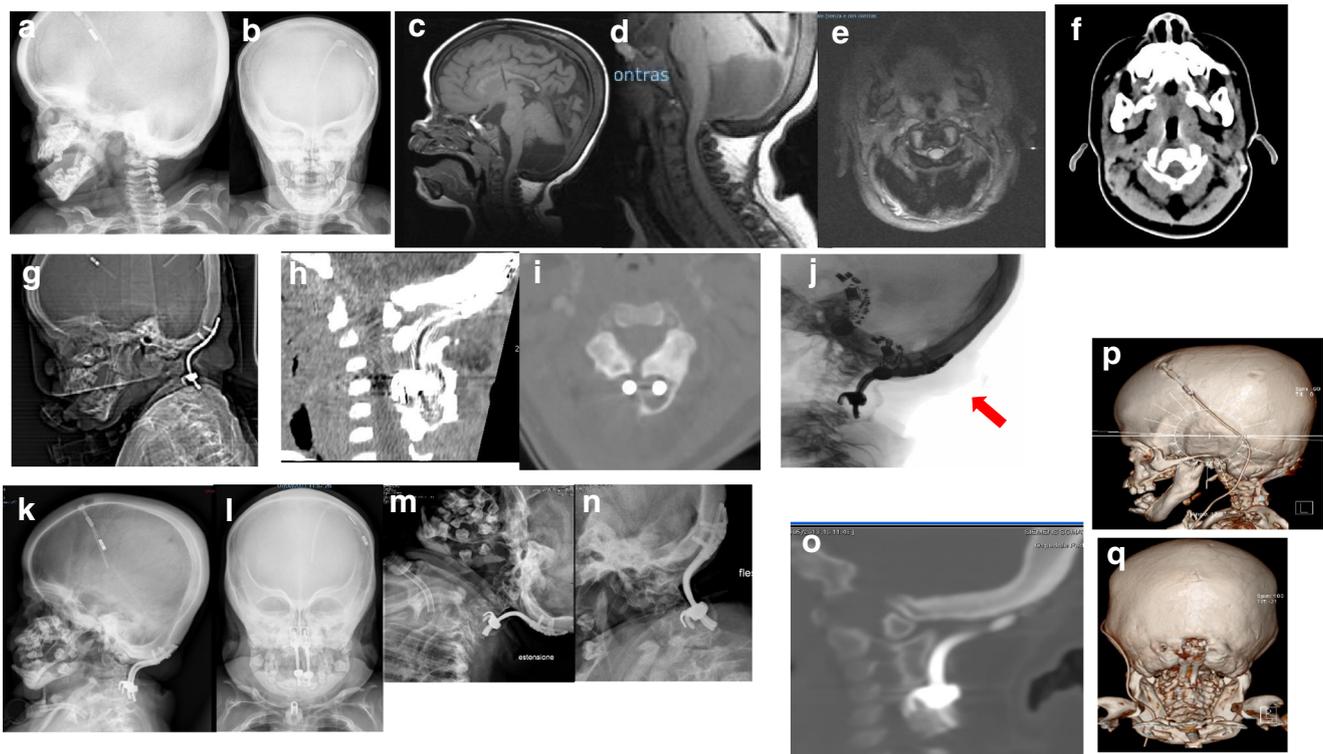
I.V., a 4-year-6-month-old girl affected by severe MPS I; a and b: treated by ventricular derivation for hydrocephalus, developed tetraplegia; c, d, and e MRI and f CT show cervical canal stenosis; she has been treated by posterior cervical decompression and occipital cervical stabilization with rods, occipital screws, and cervical hooks; g lateral radiograph after surgery, h and i CT scan after surgery; j at 24 months FU
